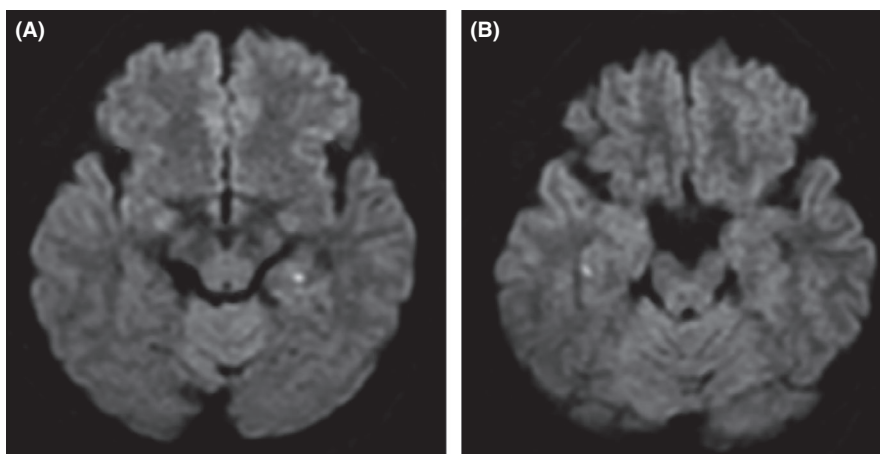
MRI of the brain revealed a single punctate focus of restricted diffusion within the bilateral hippocampal regions. (A), left hippocampal region; (B), right hippocampal region
